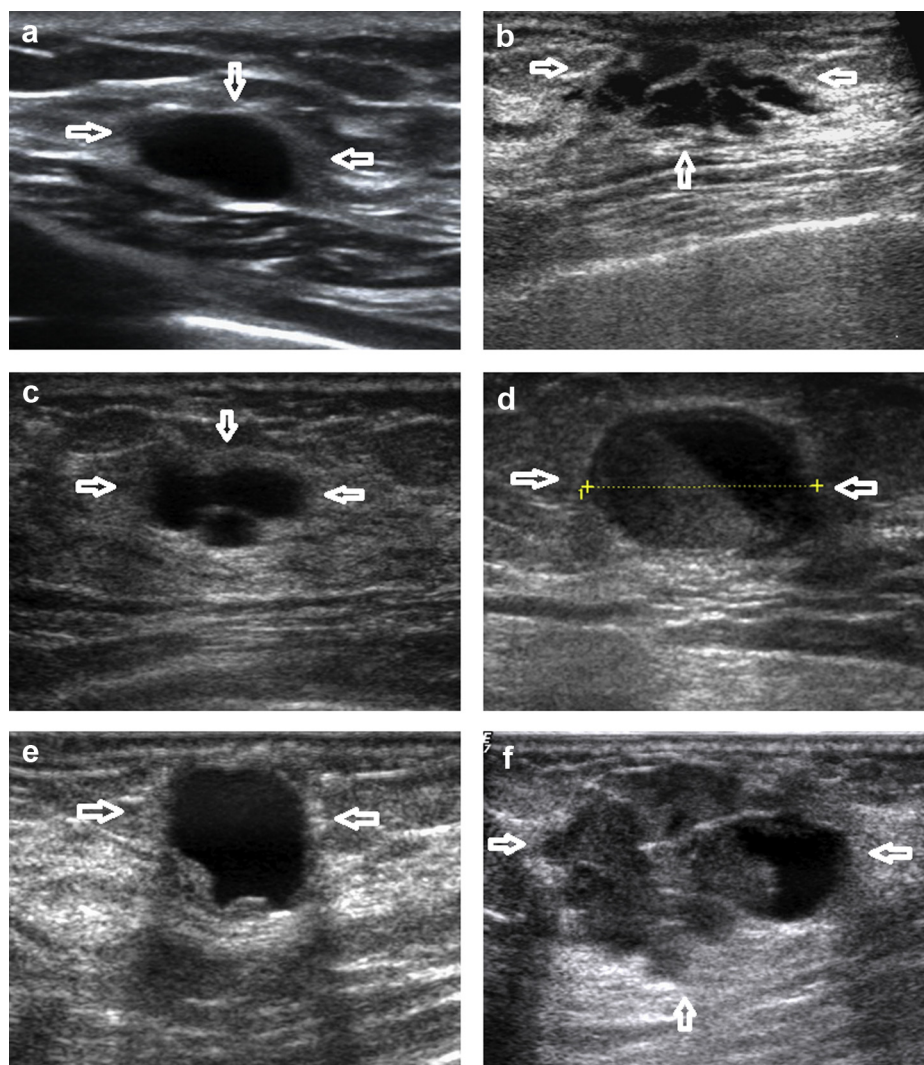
Categories of cystic breast lesions (*arrows*) based on automated breast volume scanning sonographic imaging. (a) Type I simple cyst exhibiting an anechoic area associated with a thin wall, accompanied by posterior echo enhancement. (b) Type II clustered cysts revealing no echo or solid contents within. (c) Type III large cystic masses with perceptible small, thin septa. (d) Type IV complex cyst with heterogeneous, low-level echoes, fluid cell debris, and fluid–fluid interface formed by liquid and cell debris. (e) Type V predominantly cystic masses with >50% cystic contents and with characteristics of thick walls with or without septa (>0.5 mm) or solid lumps within the wall. (f) Type VI predominantly solid masses with <50% cystic contents, with predominantly solid contents accompanied by eccentric cystic foci.
